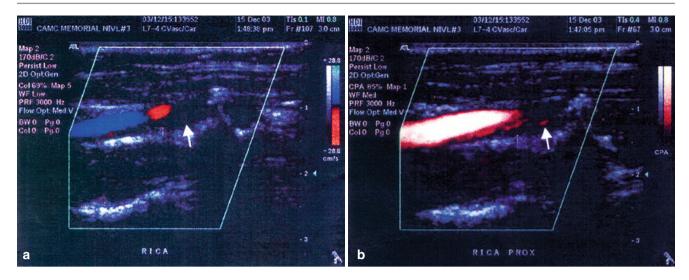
(a) Color duplex imaging of a right internal carotid artery suggesting total occlusion (*arrow*). (b) Power Doppler image of same artery showing string sign (*arrow*), i.e., subtotal occlusion
